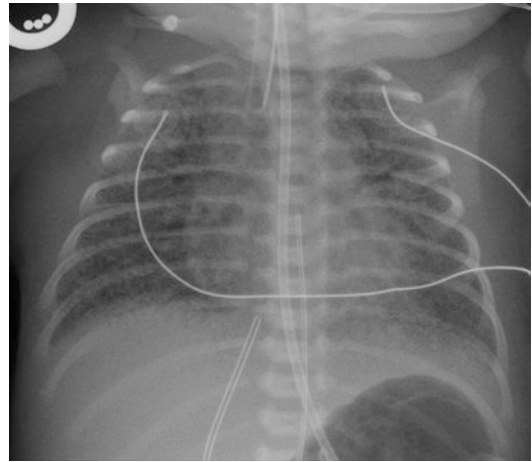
PPHN. Radiograph shows symmetrical hyperlucent lungs and decreased pulmonary vascularity in a 1-day-old neonate
